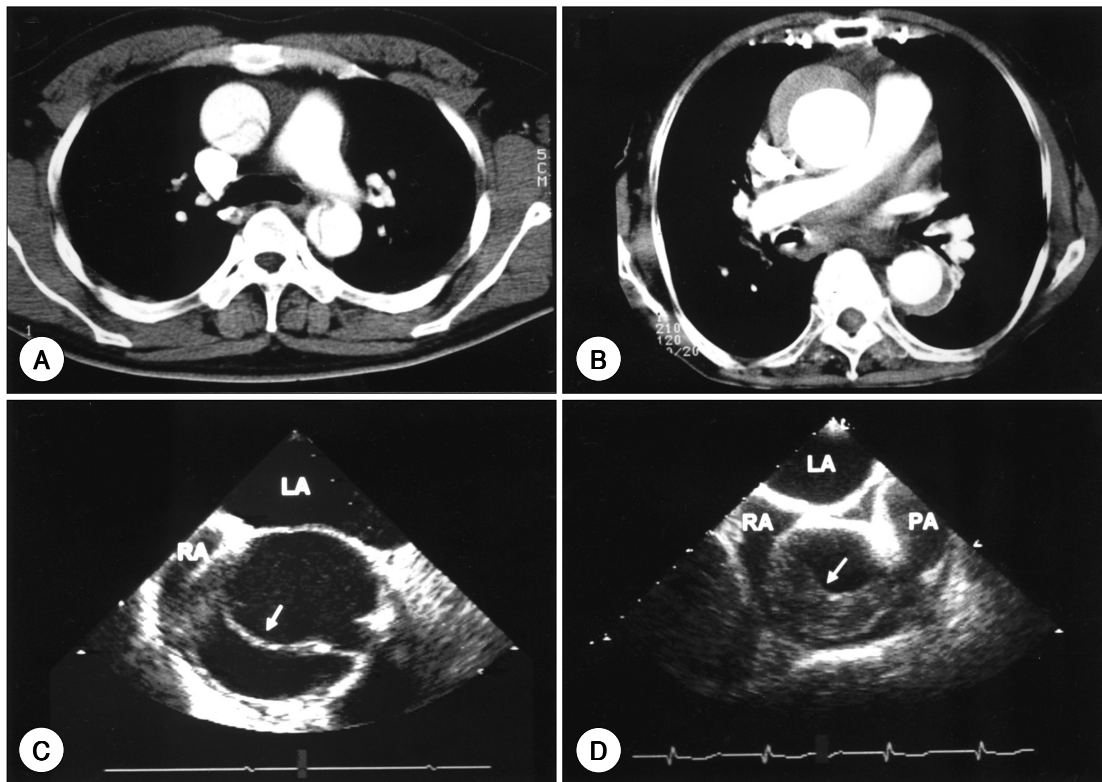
Representative x-ray computed tomograms (A & B) and transesophageal echocardiograms at the basal horizontal view (C & D) in proximal aortic dissection and intramural hemorrhage. 'Double-channel aorta' with intimal flap is characteristic in aortic dissection (A & C), whereas crescentic aortic wall thickening without any evidence of flow communication in aortic intramural hemorrhage (B & D).
